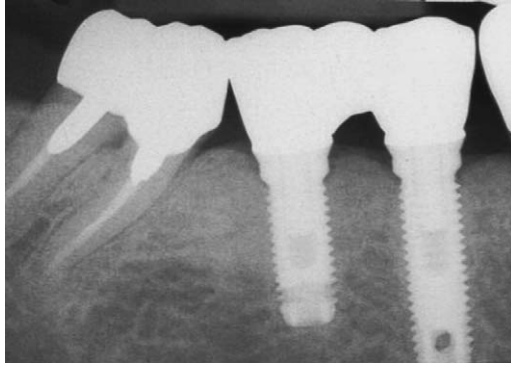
Periapical radiograph of two submerged (two-piece) dental implants placed in the posterior mandible. The final crowns are connected together. Note the angular bone loss mesial and distal of each implant down to the level of the first thread of the implants. This bone loss is characteristic for this type of two-piece implant.
